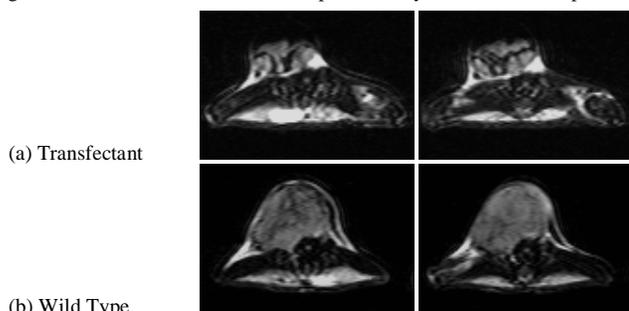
The T2-weighted images from one wild type tumor and one transfectant showing severe blood clotting and ulceration (top missing).
